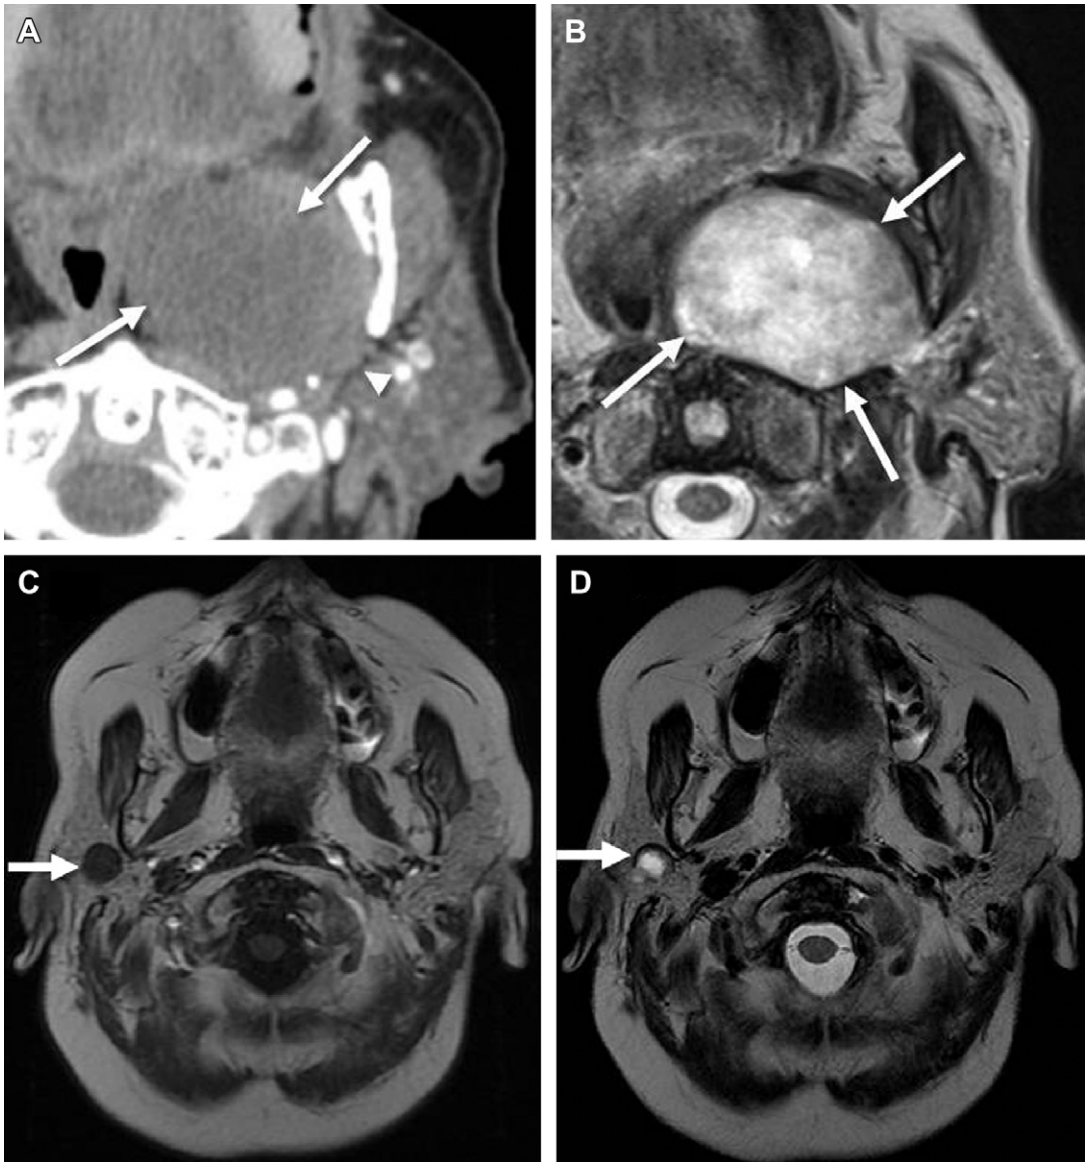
Overlap in T2 signal intensities in benign and malignant lesions of the parotid gland. (A) Axial contrast-enhanced CT shows a well-defined hypodense mass (arrows) within the left parapharyngeal space. Note the cleft (arrowhead) between deep parotid gland and mass. (B) Axial T2-weighted image shows heterogeneous T2 hyperintensity (arrow). On surgical resection this was a benign mixed tumor. (C) Axial T1-weighted image in a different patient shows a 1.3-cm well-defined low T1 signal mass (arrow) in the right parotid gland. (D) Axial T2-weighted image shows marked T2 hyperintensity (arrow) centrally in this necrotic metastatic lymph node from lung carcinoma.
